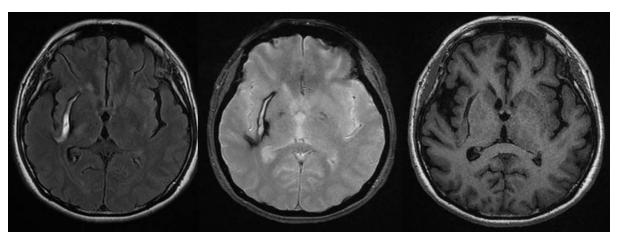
MRI Brain at 6 months post-haemorrhage
